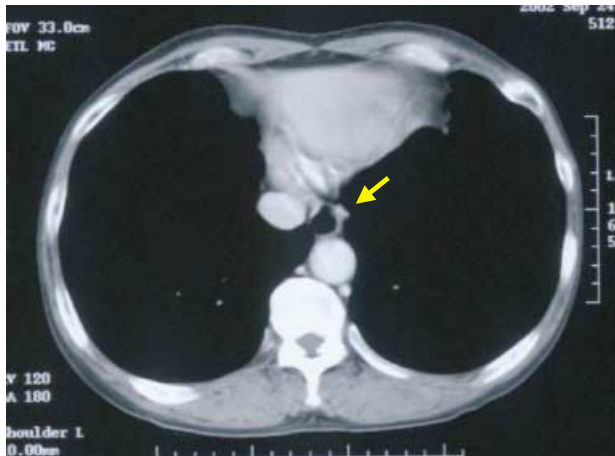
Chest CT revealing a tumor at the anterior wall of the thoracic esophagus.
